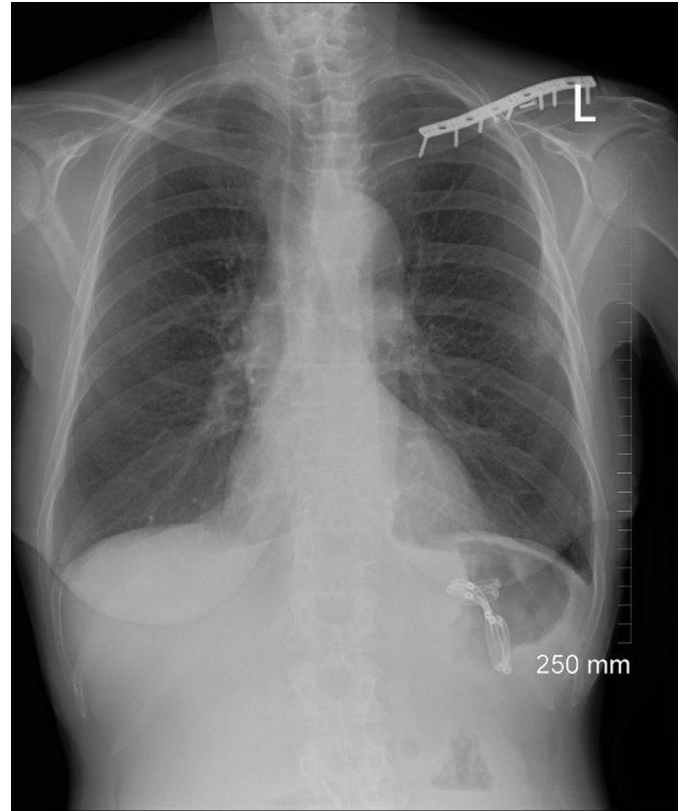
Chest X-ray 5 months post endoscopic treatment of pancreatico-pleural fistula.
